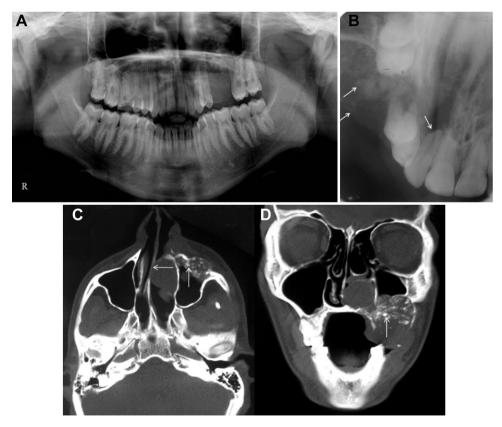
Radiographic findings of low-grade osteosarcoma of maxilla. (A) Orthopantomograph showing a well-defined relatively radiopaque shadow in the left maxilla extending from 24 to 27, suggestive of soft tissue mass, and missing 25 and 26. (B) Maxillary occlusal radiograph showing irregular specks of calcification and buccal cortical plate expansion. Periapical resorption of 22 seen. (C, D) CT axial and coronal sections revealed a fairly well-defined heterogeneous osteolytic lesion in maxillary alveolus with cortical thinning and erosion of bone from 22 to 27. Superiorly, it extended into the maxillary sinus, laterally up to the zygomatico-maxillary buttress, and inferiorly into the palatine process of maxilla and the hard palate. Numerous specks of calcification within the lesion, superior displacement of inferior turbinate and deviation of nasal septum to the right were also evident.
